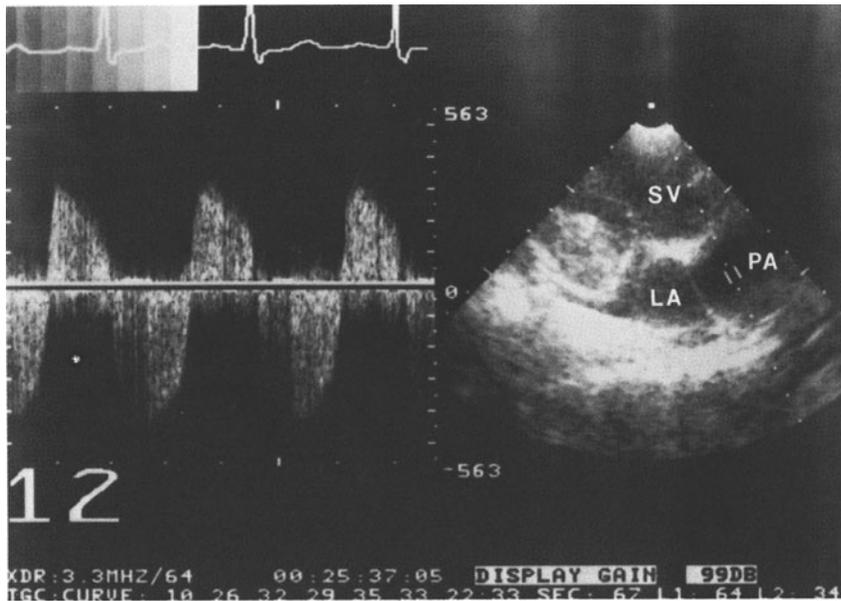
Doppler interrogation in continuous Doppler mode is performed with a phased array system that allows the direction of continuous Doppler interrogation to be steered within the sector. It uses the same transducer for continuous Doppler as it does for imaging. In the example, a patient with a single ventricle who has absent pulmonary valve syndrome and substantial pulmonic stenosis and insufficiency is under study. The pressure gradient across the pulmonary annulus was 100 mm Hg at catheterization.
